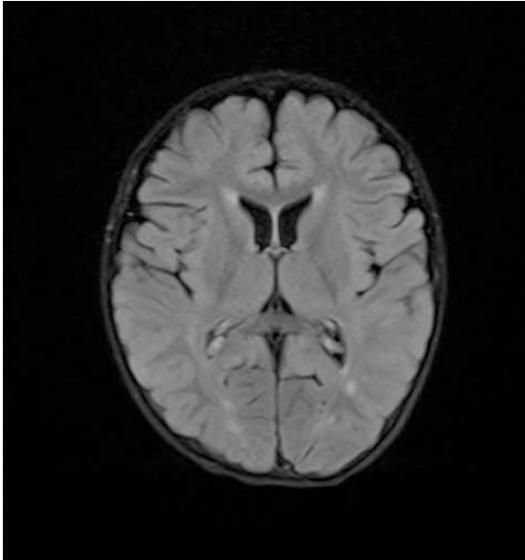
Cranial MRI revealed abnormal signals in the bilateral frontal lobes, left occipital parietal lobe, right temporal lobe, right cerebellar hemisphere, pons and medulla.
